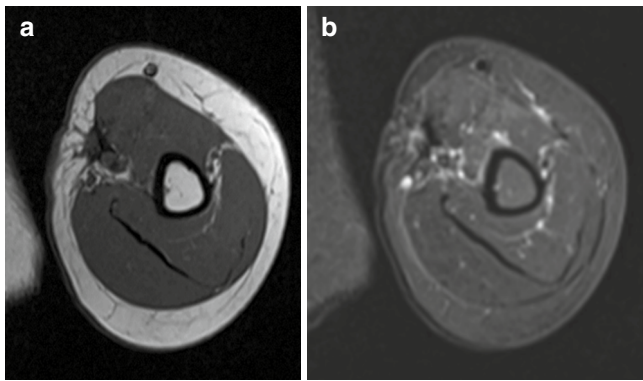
MRI 3 years after surgery. Axial sections (a) T1 sequence. (b) T2 sequence. No signs of local recurrence are observed
